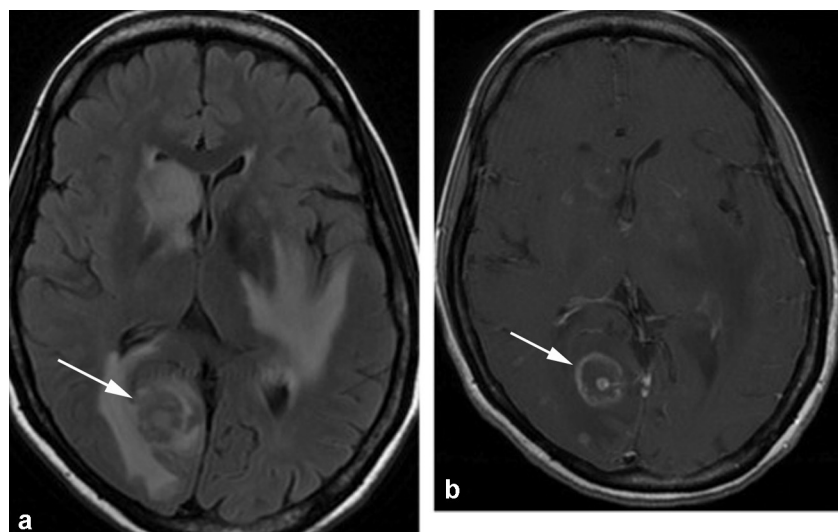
Toxoplasmosis. FLAIR axial (a) and T1 after injection (b). Multiple sub-cortical and deep lesions, enhanced after injection, surrounded by oedema. The most voluminous lesion, right occipital, presents a content in FLAIR hypointense and a typical target enhancement with an eccentric centre.
